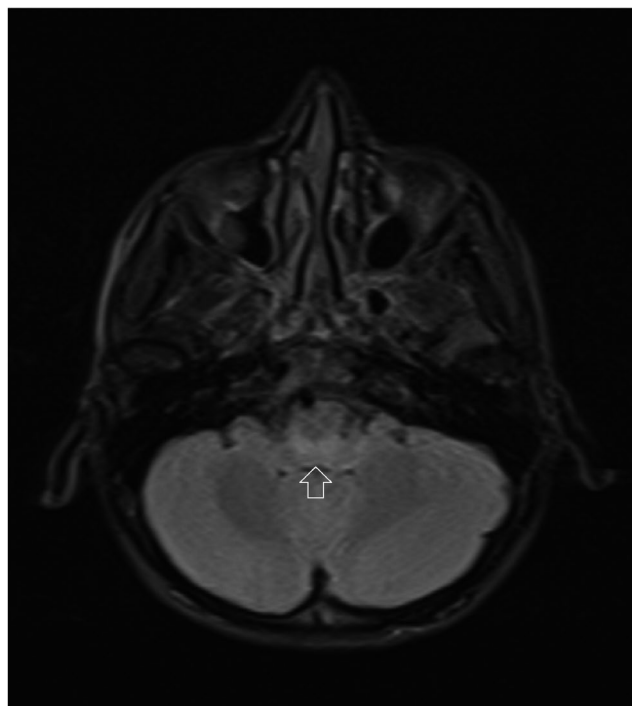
FLAIR MRI image of the patient showing subtle hyperintensity in dorsal medulla (white arrow)
